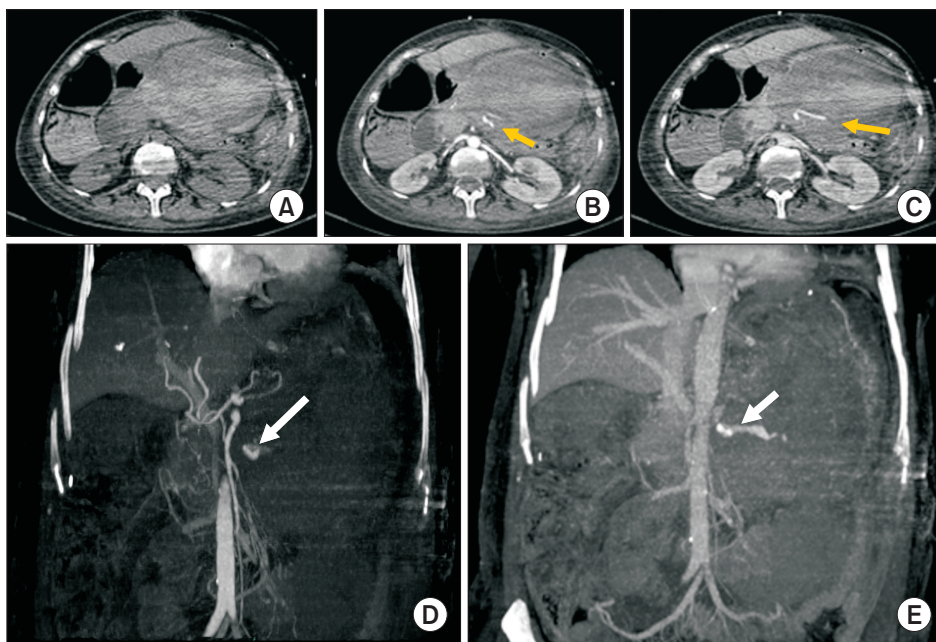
Computed tomography (CT) scan of the abdomen and pelvis. (A) Non-contrast. (B) Arterial phase. (C) Portal phase. A large acute retroperitoneal peripancreatic hematoma is observed, with contrast extravasation appearing as a jet at the body of the pancreas during the arterial phase and increasing during the venous phase (orange arrows). (D, E) Coronal maximum intensity projection reconstruction in the portal phase. White arrows indicate jet-like bleeding within the peripancreatic region.
